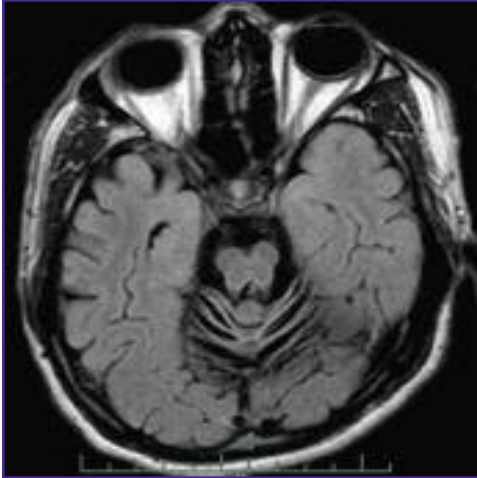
MRI brain axial view T1 images showing generalized cerebral atrophy and marked cerebellar atrophy
